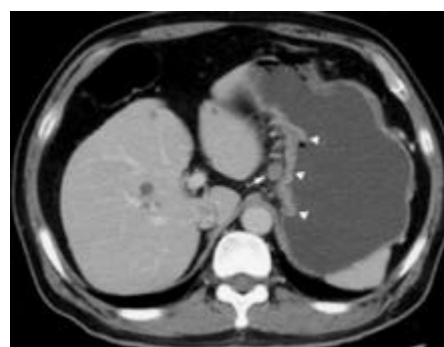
CT scan shows a metastatic lymph node (confirmed by pathologic examination) (arrow) 10 mm in short-axis diameter, which is adjacent to the primary lesion of gastric carcinoma (arrowhead).
